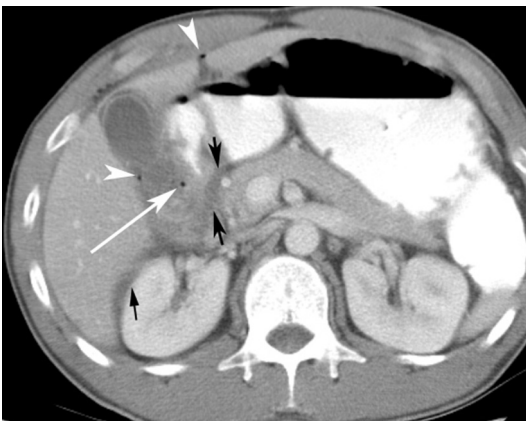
Perforated duodenal ulcer mimicking acute pancreatitis. This 52-year-old woman came to the Emergency Room with acute onset of severe abdominal pain. The amylase was mildly elevated prompting the clinical diagnosis of acute pancreatitis. The axial CT image demonstrates fluid between the pancreatic head and the duodenum and stranding in the anterior pararenal space (black arrows), but the duodenal wall is thickened with free air next to it (long white arrow), in the gallbladder fossa, and in the falciform ligament areas (white arrowheads), indicative of a perforated duodenal ulcer. Surgery confirmed the perforated ulcer and absence of pancreatitis.
